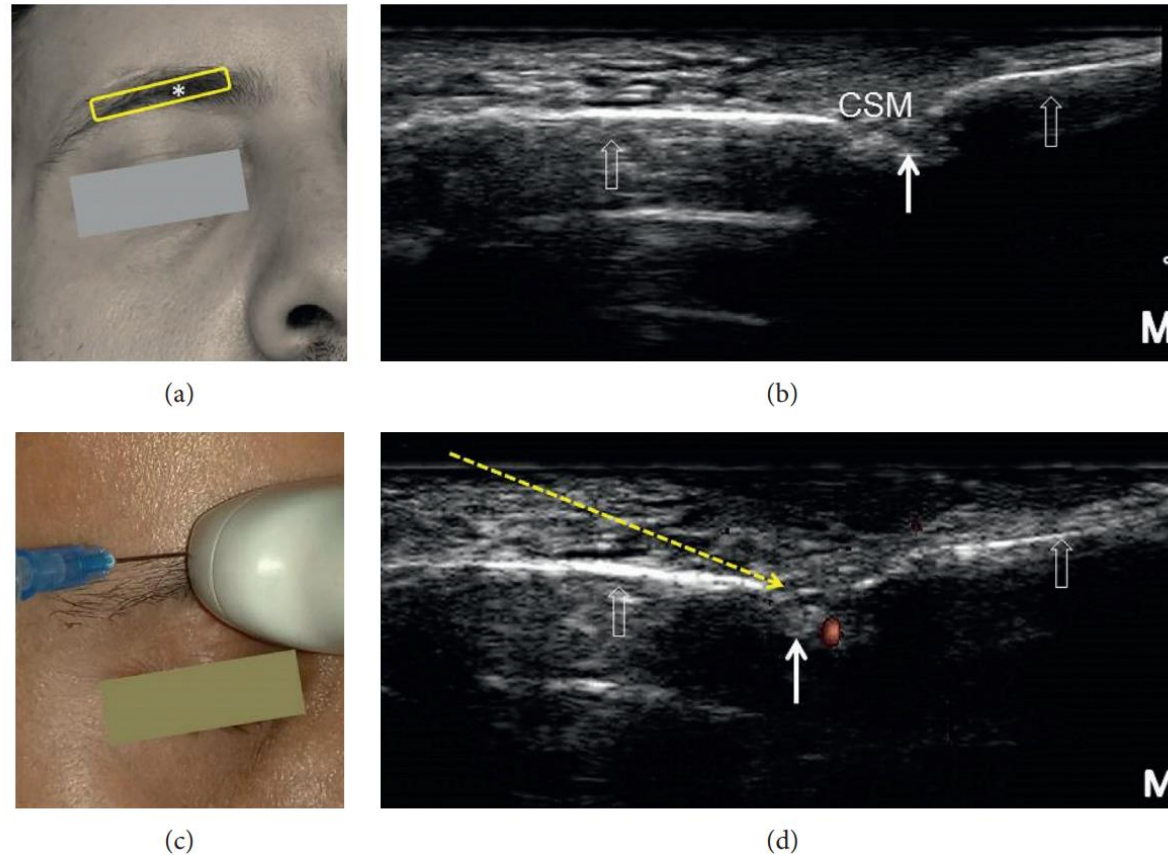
Sonoanatomy and ultrasound-guided injection technique for the supraorbital nerve: (a) the position of the transducer (yellow rectangle), (b) ultrasound imaging of the supraorbital nerve emerging from the supraorbital notch, (c) introducing the needle in the lateral-to-medial direction using the in-plane approach to target the supraorbital nerve, and (d) power Doppler image of the supraorbital vessels. The asterisk (*) denotes the supraorbital notch on the face. The empty white arrows denote the supraorbital margin. The solid white arrow denotes the supraorbital nerve. The yellow dashed arrow denotes the needle trajectory. CSM: corrugator supercilii muscle and M: medial side. All the pictures were obtained from the face of the first author.
